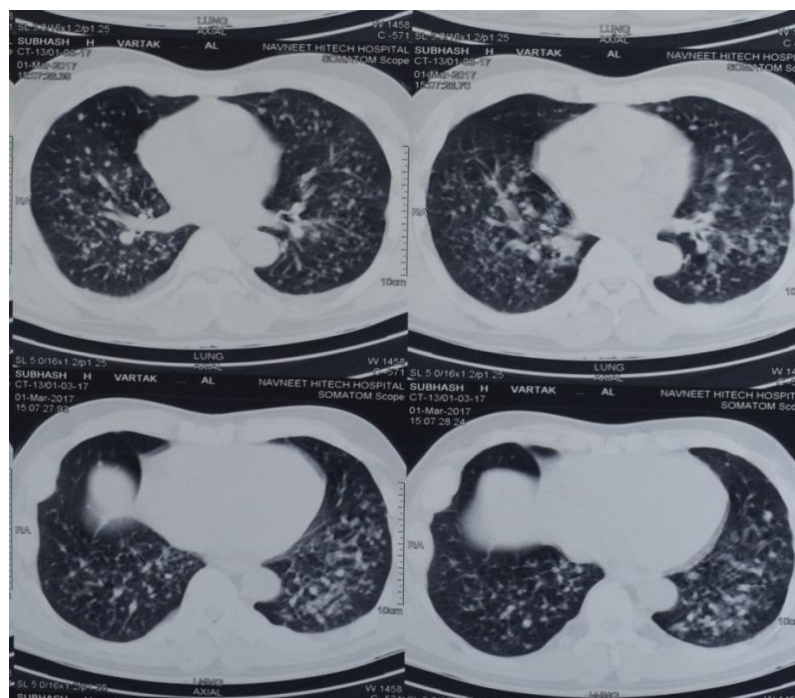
CT Scan - Axial Section of the Lung showing moderate to enlarged soft tissue mass in the lung parenchyma
